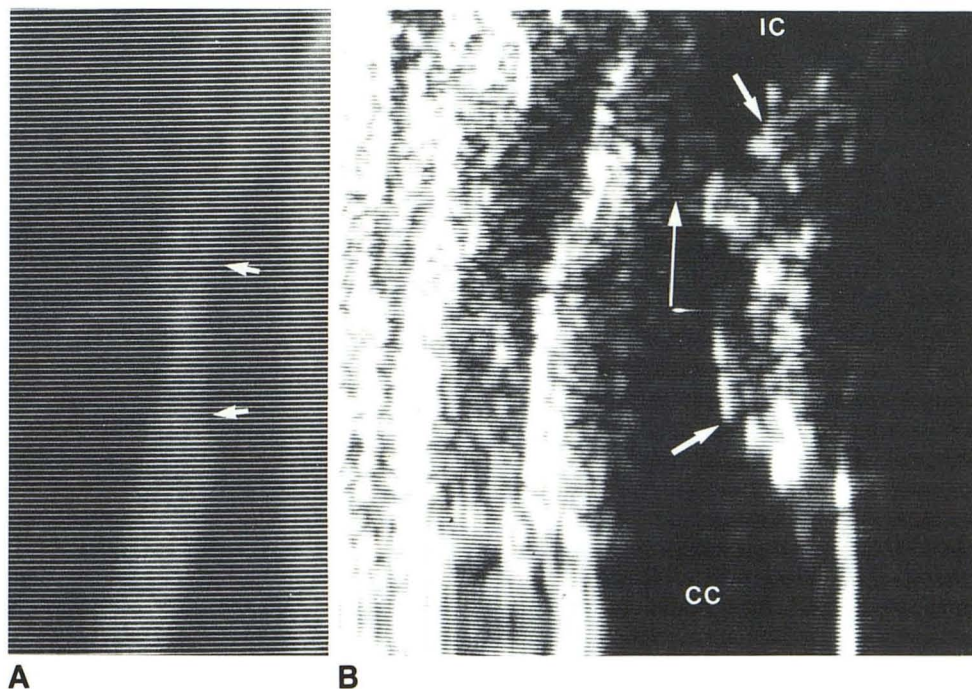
A, DSA. Minimal deformity of contour of proximal internal carotid artery (*arrow*). B, Sonogram of proximal internal carotid artery. Obvious, though small, atheromatous plaque (*arrow*). Skin line is on reader's left.
